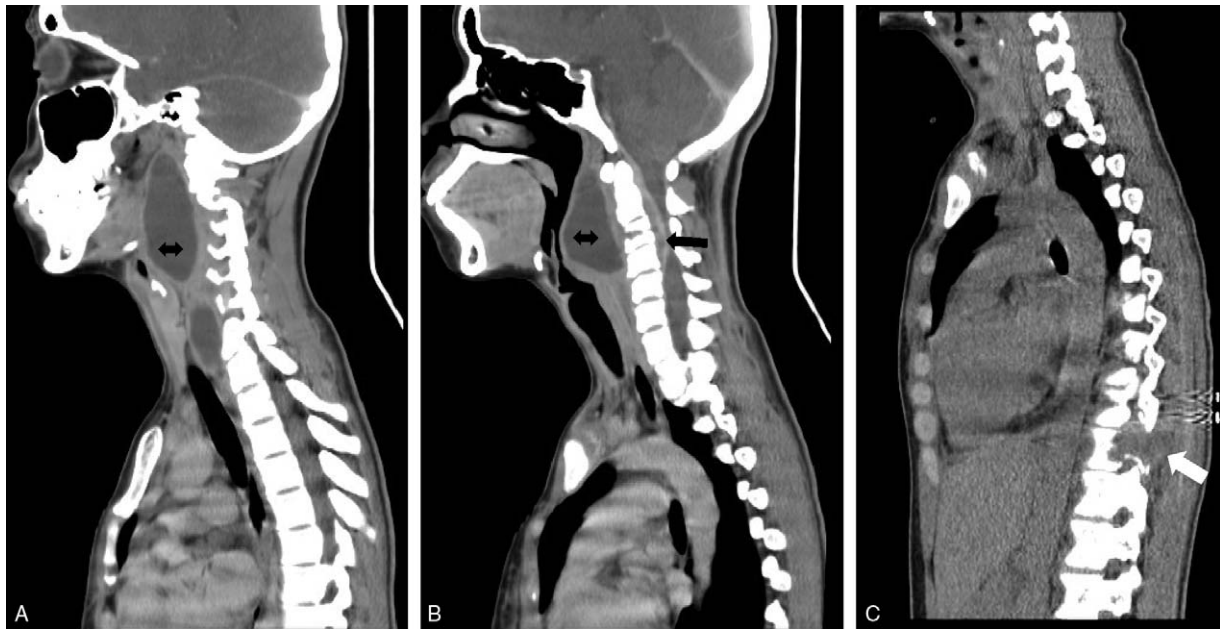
A, B, C, Sagittal computed tomography (CT) scan of the neck showed retropharyngeal abscess spanning from the level of the nasopharynx down to the level of the supraclavicular fossa (double-ended black arrow) and extending to the epidural space of the spinal canal at C1-C3 level (black arrow), with the destruction of the C3 vertebral body. Destruction of T9 vertebra with left paraspinal mass was also found (white arrow).
